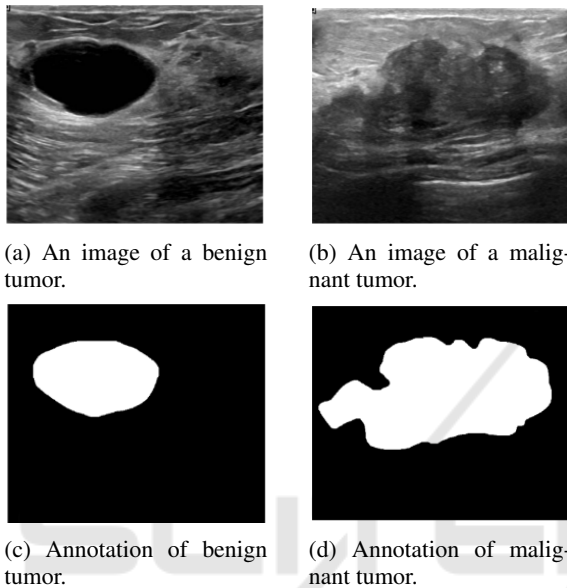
Examples of breast ultrasound images from the Dataset and their respective annotations.
